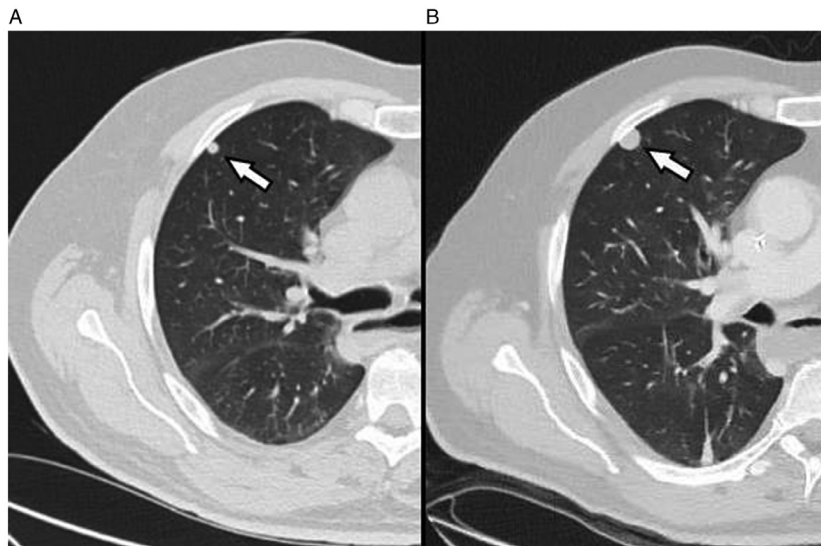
Two consecutive CT scans showing that the right upper lobe lung nodule (white arrows). (A) Initial size of the nodule (6 mm) and (B) the nodule after 1 month (12 mm).
